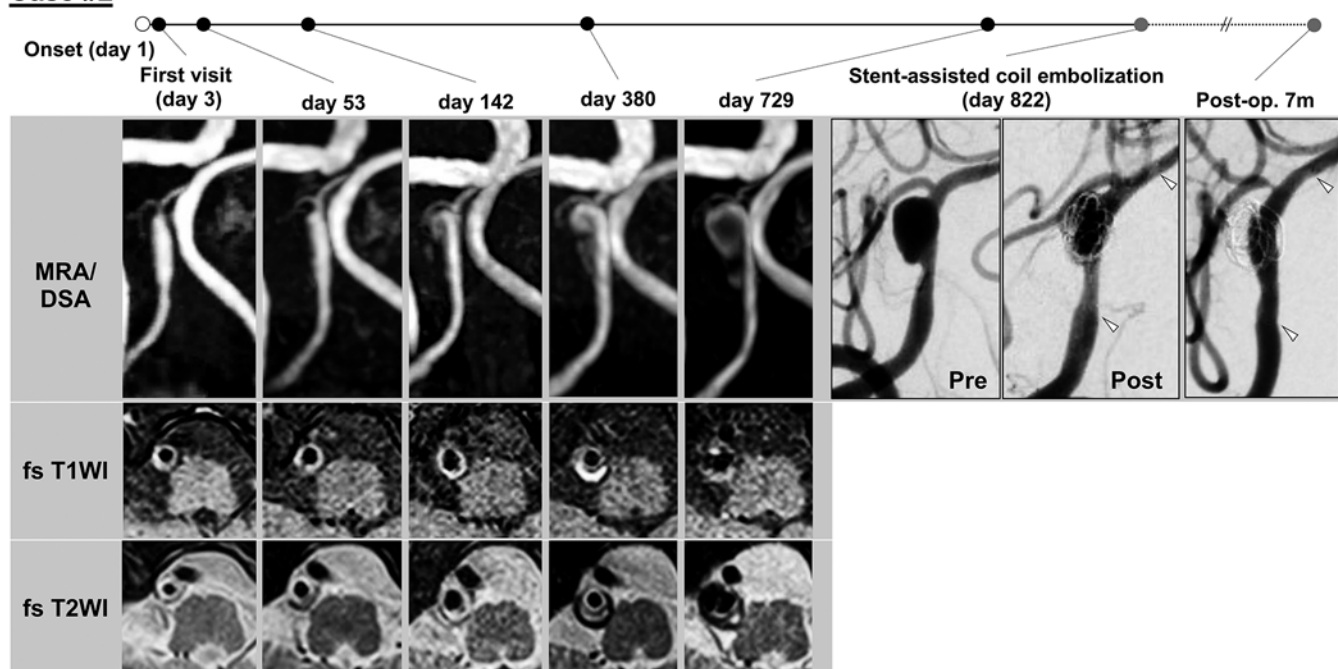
Case 2. The radiological transition with a continuously enlarged aneurysm from the early onset of isolated headache iVAD to the chronic phase of the disease. Note that fat-suppressed T1-weighted imaging (fs T1WI) showed a hyperintense intramural hematoma continuously spreading to the periphery of the arterial wall. Arrowheads in the postoperative images indicate the ends of the stent. m = months; post = postoperatively; pre = preoperatively.
